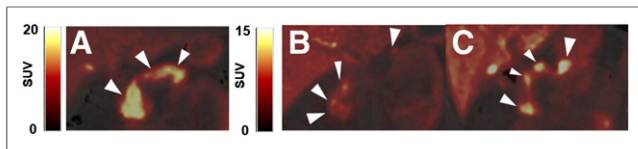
Representative coronal PET/CT images of ^{11}C -(+)-PHNO in pancreas (arrowheads) for HC (A), C-peptide-deficient T1DM subject (B), and T1DM subject with detectable C-peptide (C). All SUV images are summed from 20 to 30 min. (A) SUV scale 0–20. (B and C) SUV scale 0–15.
